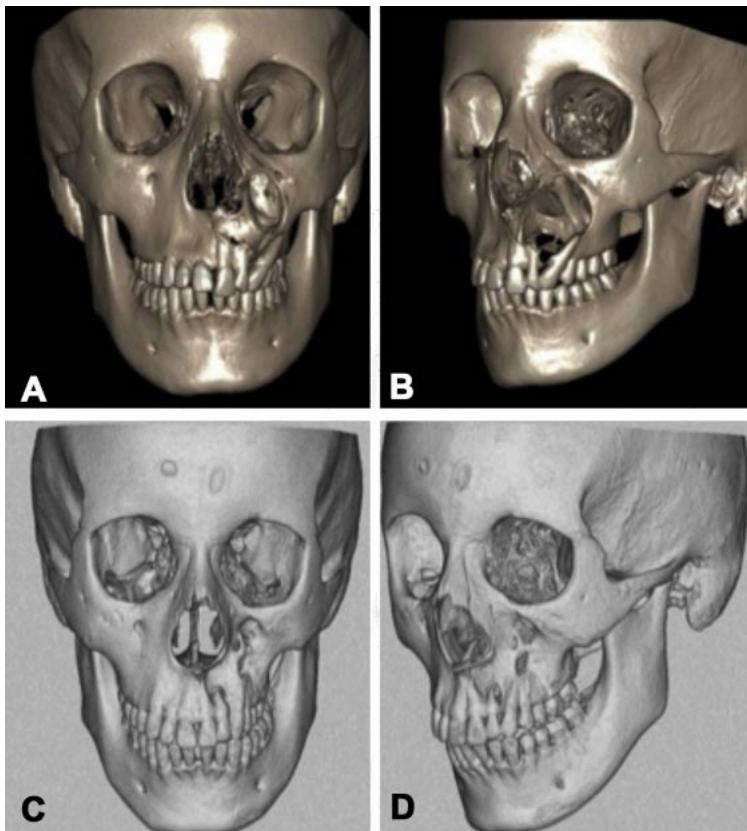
Three-dimensional reconstruction of CT scans. A. preoperative front view. B. preoperative 3/4 view. C. postoperative front view. D. postoperative 3/4 view.
